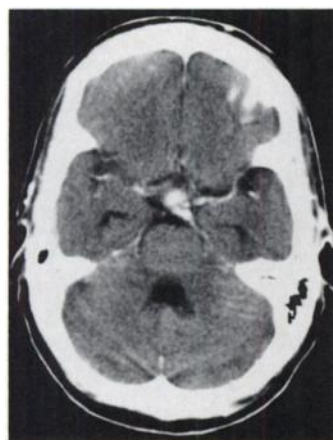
CT scan of the head with i.v. contrast. An ill-defined enhancing mass in the suprasellar cistern is consistent with CNS sarcoidosis.
